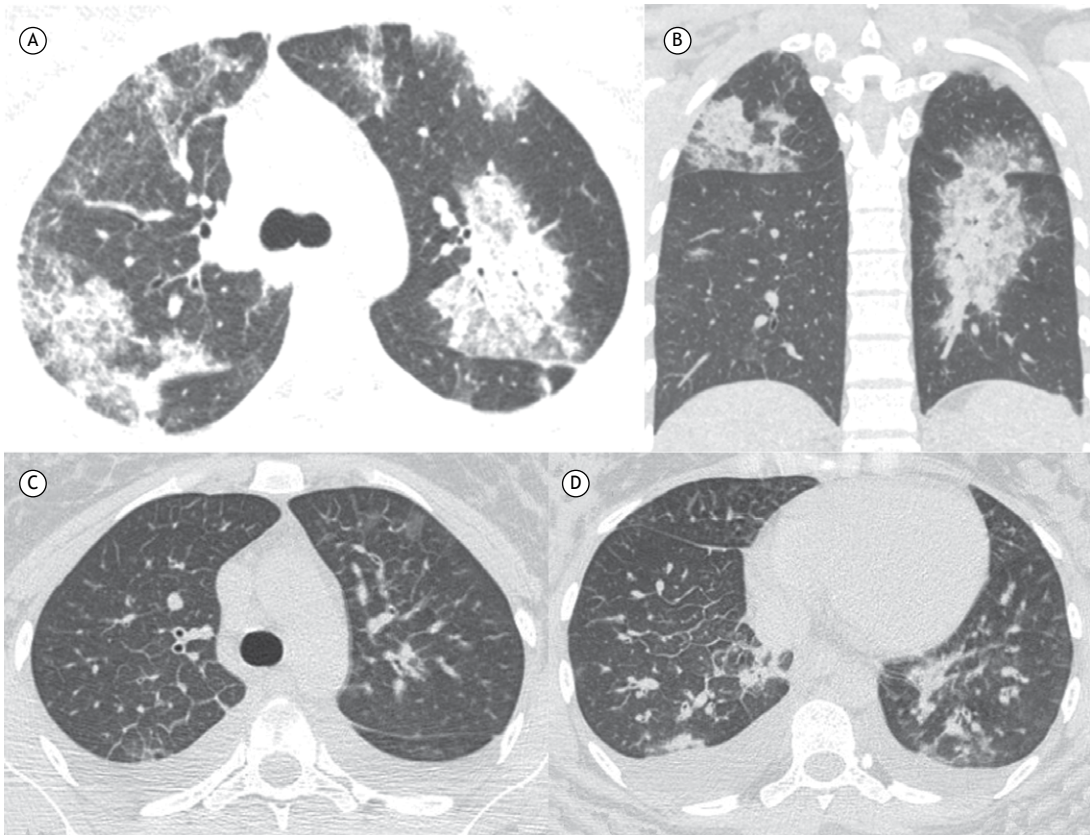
Two patients diagnosed with dengue. In A and B, a 37-year-old woman with severe dengue and pulmonary hemorrhage. Axial CT scan (A) and coronal reconstruction (B), showing bilateral multifocal areas of consolidation and ground-glass opacity. In C and D, a 51-year-old woman with severe dengue and findings of pulmonary edema. Axial CT scans of the upper and lower lobes (C and D, respectively), showing bilateral peribronchovascular and interlobular septal thickening, together with multifocal areas of mild consolidation and ground-glass opacity in both lungs. Note also the bilateral pleural effusion.
